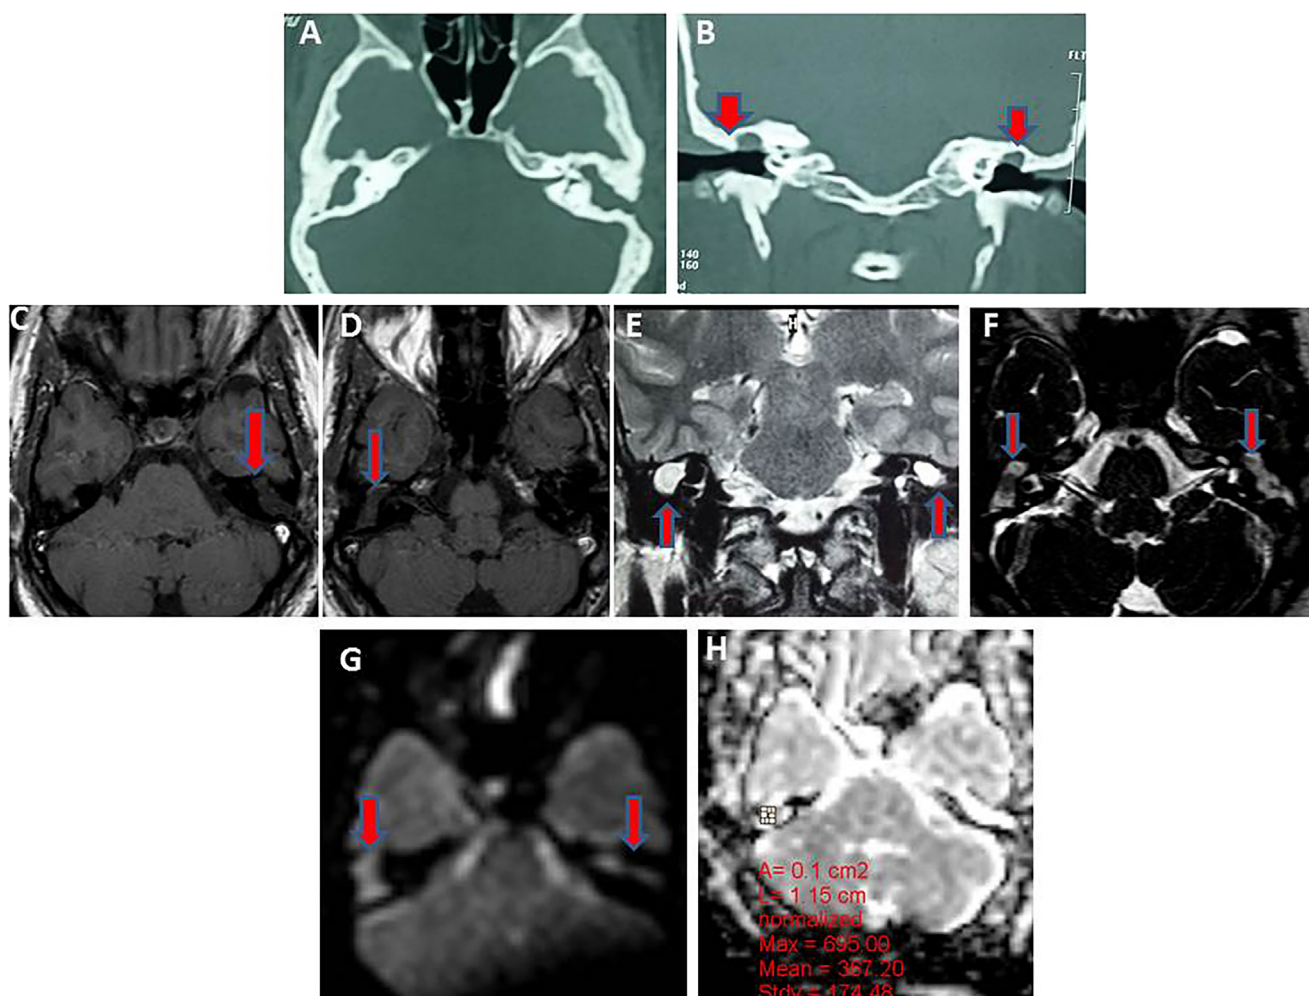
Bilateral recurrent cholesteatoma of a 33y old woman who underwent CWU middle ear surgery at both sides. (A and B) Axial and coronal CT cuts showed opacified attic on both sides by non-dependent tissue density lesion associated with absent ossicles (red arrow). (C) Axial T1WI right and (D) left ear, (E) Axial CISS and (F) Coronal T2W SE showed a soft tissue lesion in the middle ear left of both ears of low signal in T1WI and high signal intensity in T2WI and CISS (red arrow). (G) Axial DWI fast SE image obtained with a b factor of 1000 s/mm² showed markedly high signal intensity of the cholesteatoma on both sides (red arrow). (H) ADC (mean 759, 724 × 10⁻³ mm²/s).
